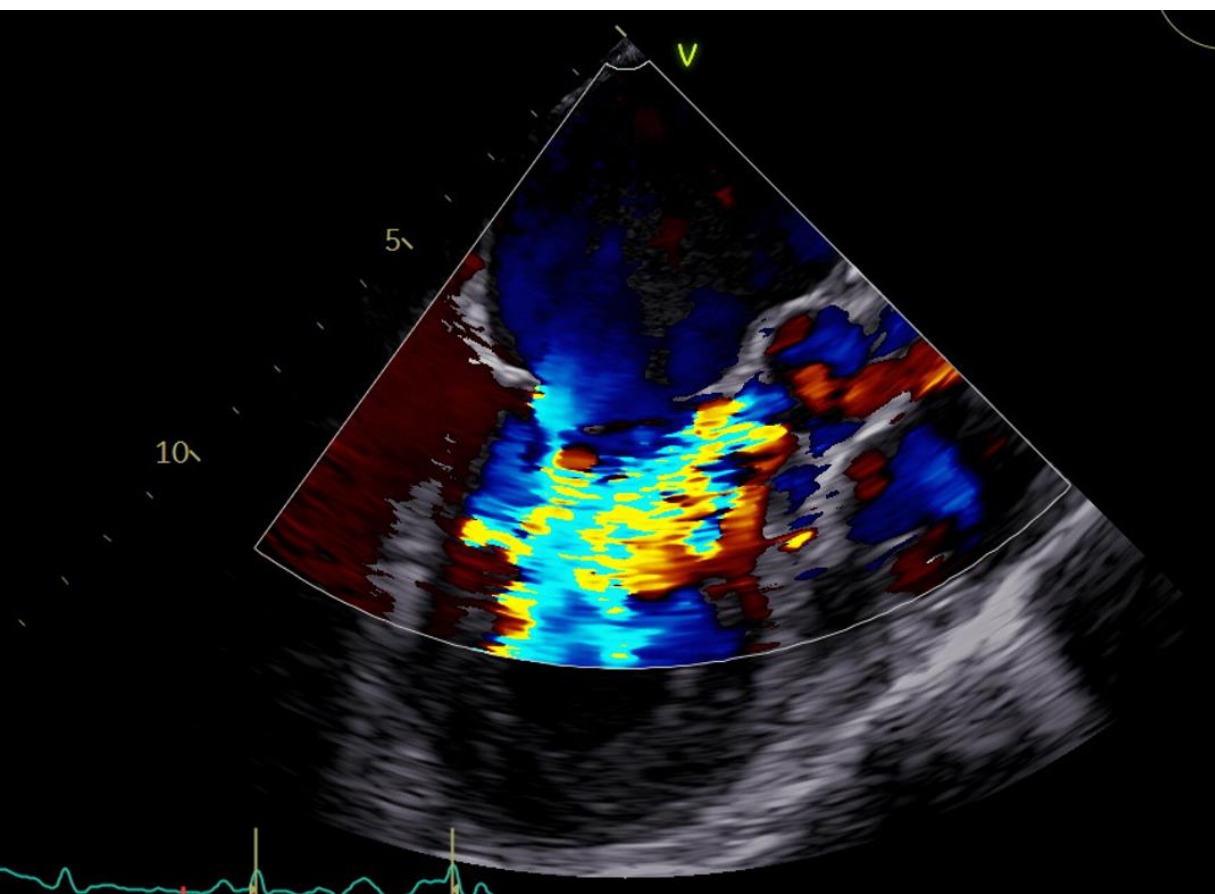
Valve vegetation as seen on TEE with doppler
